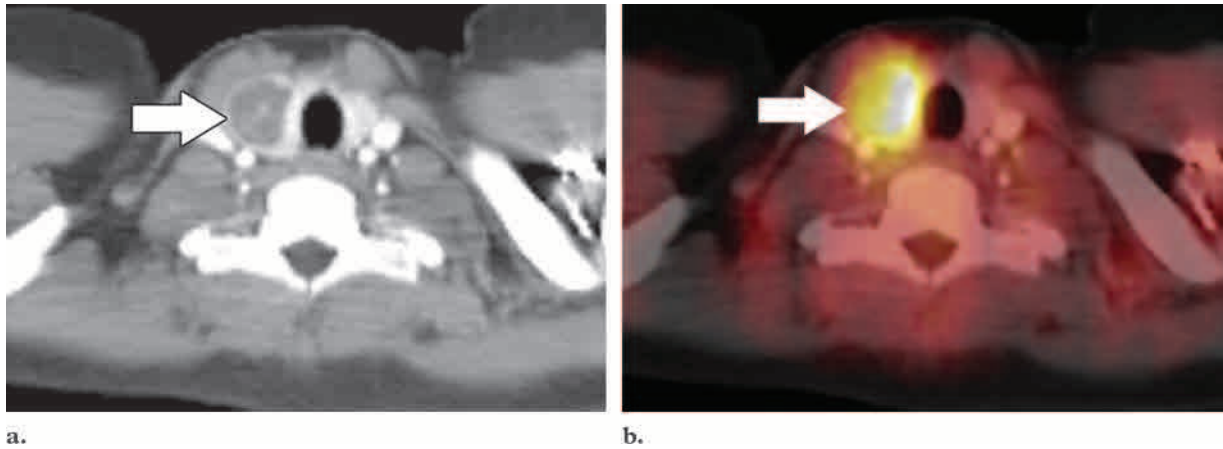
Hürthle cell carcinoma. Axial CT (a) and fused PET-CT (b) scans help localize a focal abnormality (arrow) to a 2.5-cm cystic thyroid mass. Biopsy of the mass helped confirm a Hürthle cell carcinoma of the thyroid gland.
